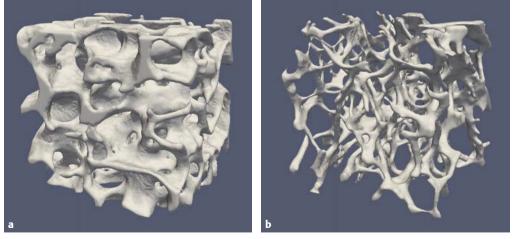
Age-related changes in trabecular bone quality. Besides drastic loss in bone mass, plate-like structures change into rod-like structures with aging as shown by these micro-computed tomographic images at age 35 (a) versus 73 (b) years. (Images by courtesy of Prof. Dr. Ralph Müller, Institute for Biomechanics at the ETH Zurich, Switzerland).
